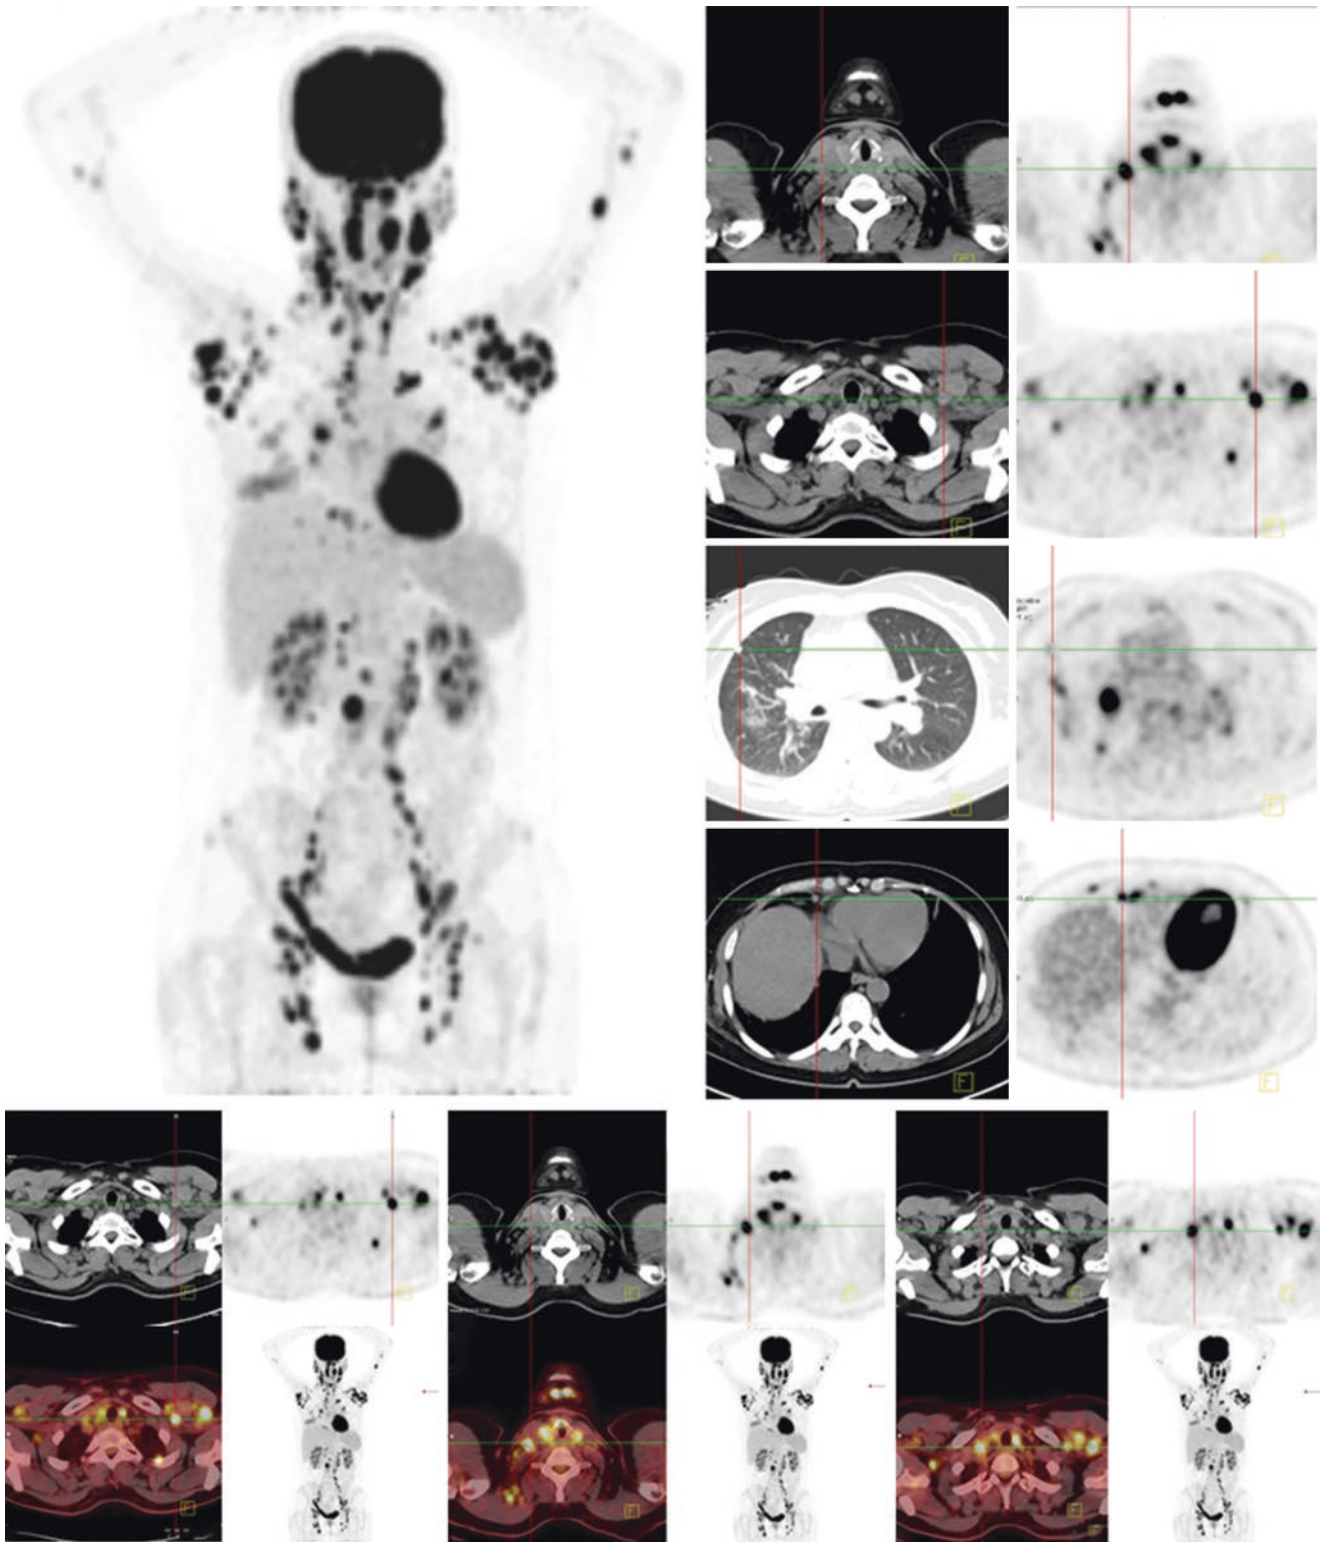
PET/CT—multiple lymph node shadows, partial enlargement, increased metabolism
